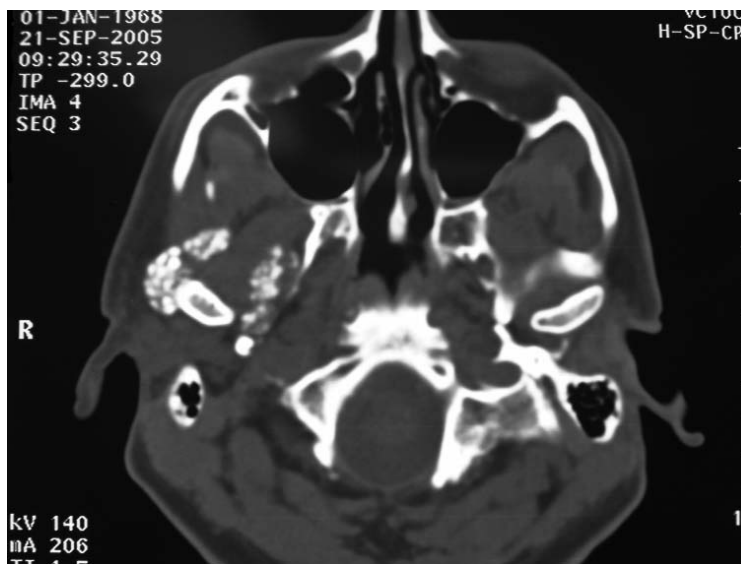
Axial computed tomography with radiopaque masses appreciated proximal to right temporomandibular joint medially and laterally.
